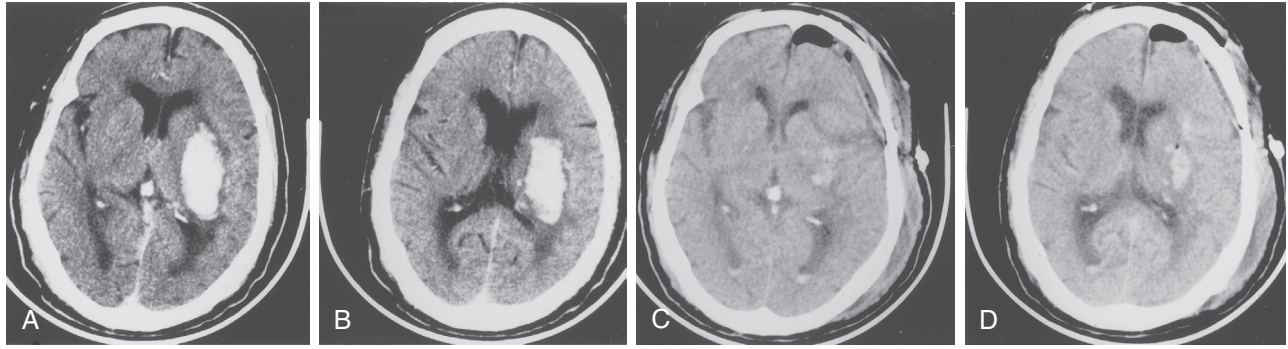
Surgical intervention for intracerebral hemorrhage (ICH). (A) Admission CT scan of a 54-year-old patient with an acute hypertensive putaminal hemorrhage, 42 mL in volume, causing hemiparesis and mild confusion. (B) CT scan of the same patient on day 1, with patient becoming more lethargic. (C and D) CT scans showing evacuation of the intracerebral hemorrhage (ICH) via open craniotomy, with mild residual ICH.
